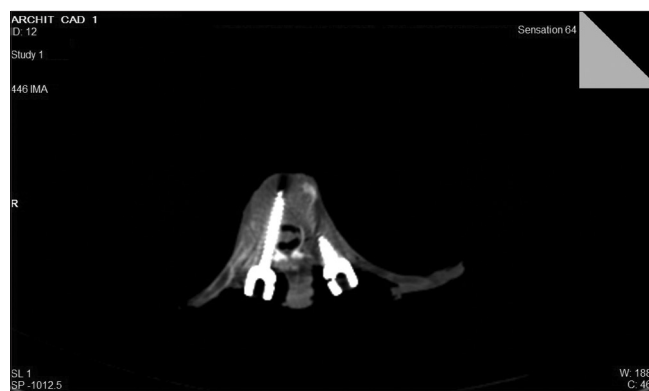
Computed tomography scan showing medial pedicle wall violation
